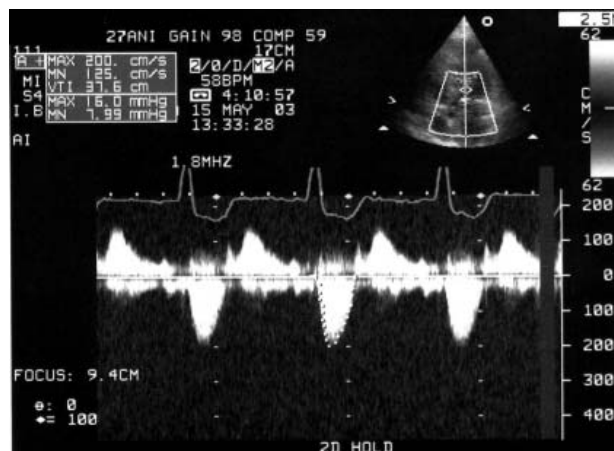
Post-procedural echocardiography - without LV/Ao gradient.
